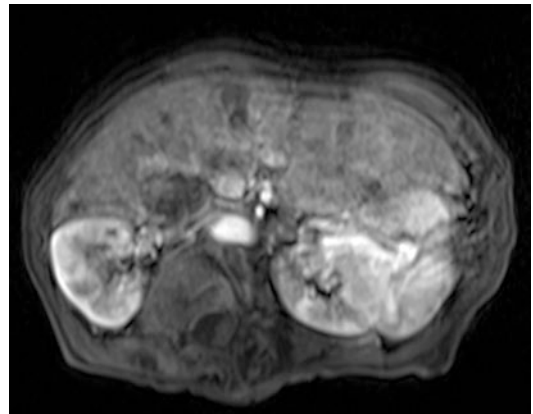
Motion artifacts. Axial MR image of the liver shows severe motion blurring, making detection of any abnormality difficult. The patient was unable to breath hold
